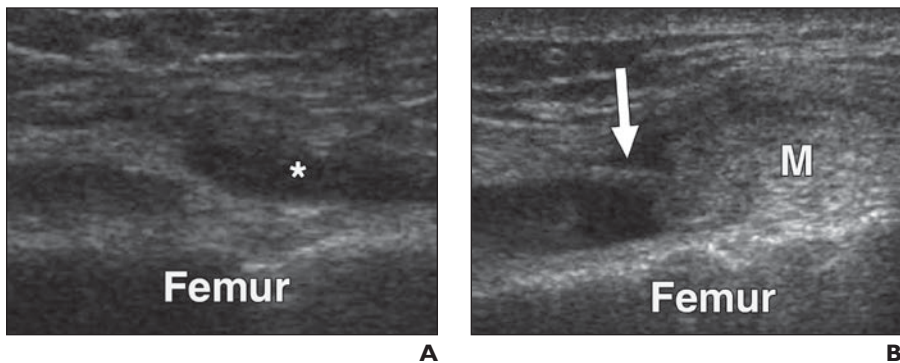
44-year-old man with painful mass that popped out over his lateral knee with flexion and disappeared with extension. MRI of knee, obtained with knee in extension, failed to find cause of his symptoms.
